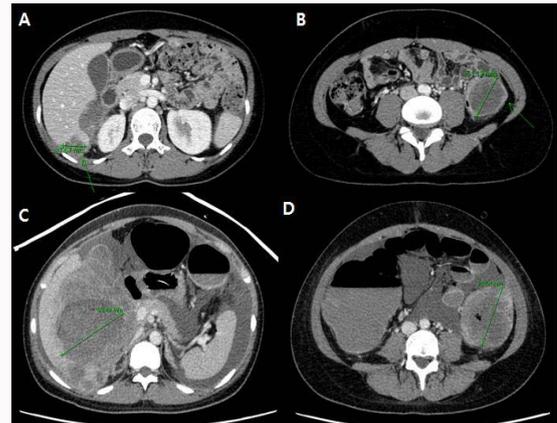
CT at admission for abdominal pain and mechanical ileus and 16 days later. CT at admission: (A,B) Seeding mass at perihepatic area (2.7 cm) and left paracolic gutter (5.2 cm). Follow up CT 16 days later: (C,D) More progressive disease with obstructive ileus due to descending colon invasion by seeding mass. Sizes of all seeding masses in perihepatic area increased (2.7 cm to 9.8 cm) with 7.8 cm new direct invasion seeding lesion in the liver parenchyma.
